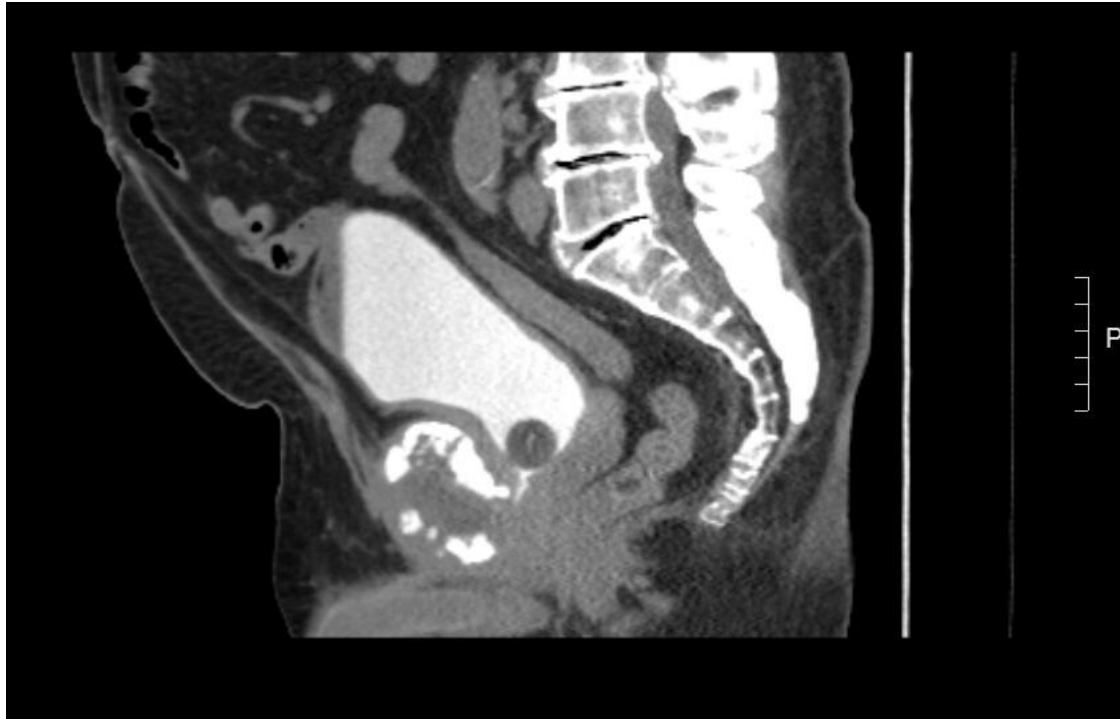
Computed tomography cystogram sagittal view with Foley catheter in situ. A small contrast leak is demonstrated from the prostatic urethra near the bladder neck to the bony fragments of the pubic symphysis.
